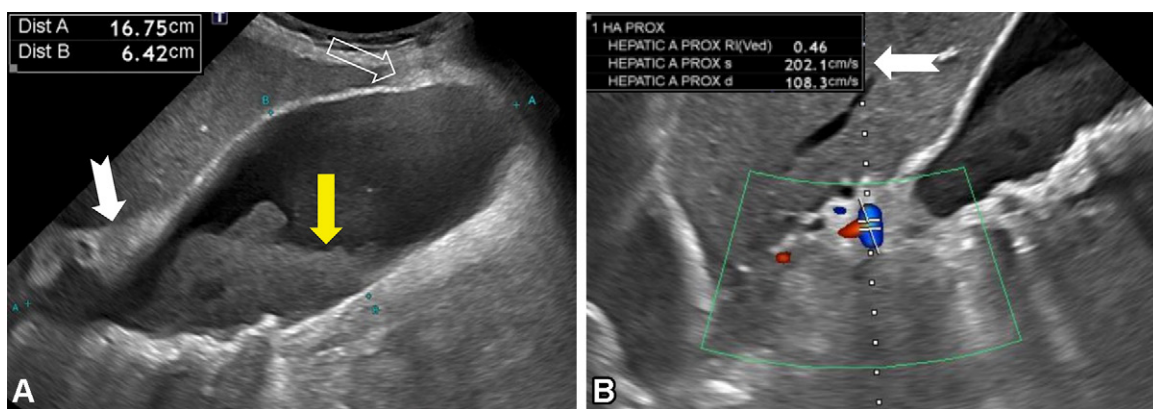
Acute cholecystitis in a 79-year-old man in septic shock. (A) Gray-scale longitudinal US image shows the gallbladder markedly distended to 16.7 × 6.4 cm, with sludge (yellow arrow) and echogenic pericholecystic fat along the gallbladder fundus (open arrow) and triangle of Calot (white arrow). (B) Color Doppler US image shows an elevated hepatic artery velocity of 202 cm/sec (arrow).
